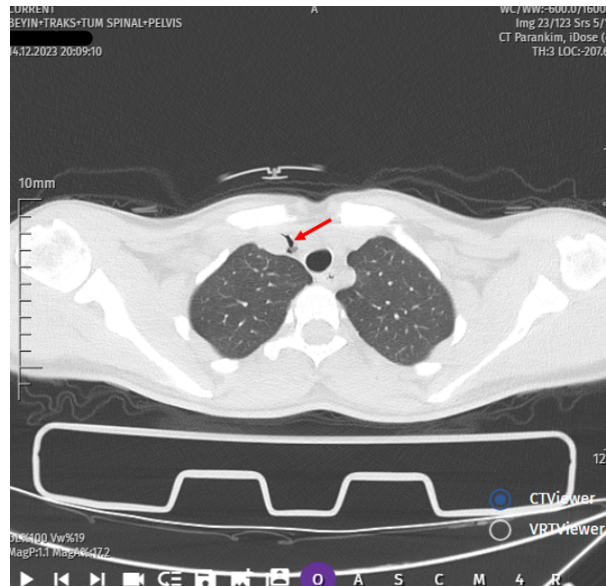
CT image of the patient.
